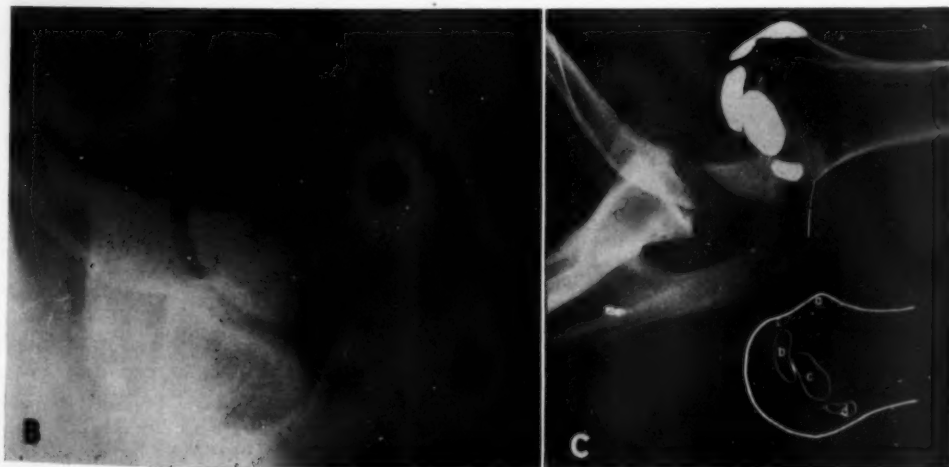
B. Roentgenogram of shoulder with patient in above position. C. Roentgen skeletal study demonstrating subscapularis muscle tendon insertion on the lesser tuberosity, *a*, in partial profile.
